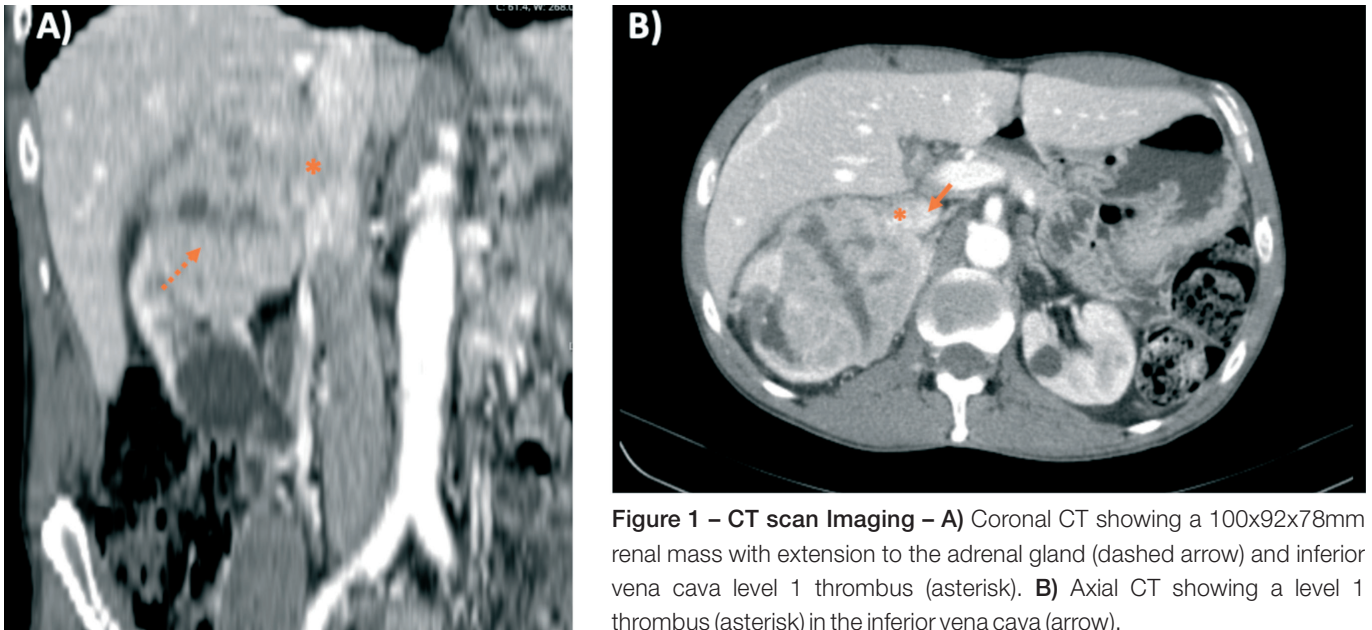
CT scan Imaging – A) Coronal CT showing a 100x92x78mm renal mass with extension to the adrenal gland (dashed arrow) and inferior vena cava level 1 thrombus (asterisk). B) Axial CT showing a level 1 thrombus (asterisk) in the inferior vena cava (arrow).
